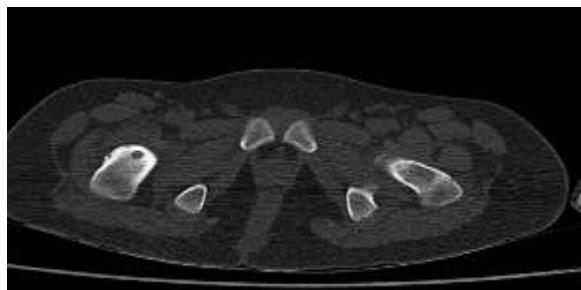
Axial CT scan shows a well-defined nidus with surrounding sclerosis in greater trochanter of right femur.
